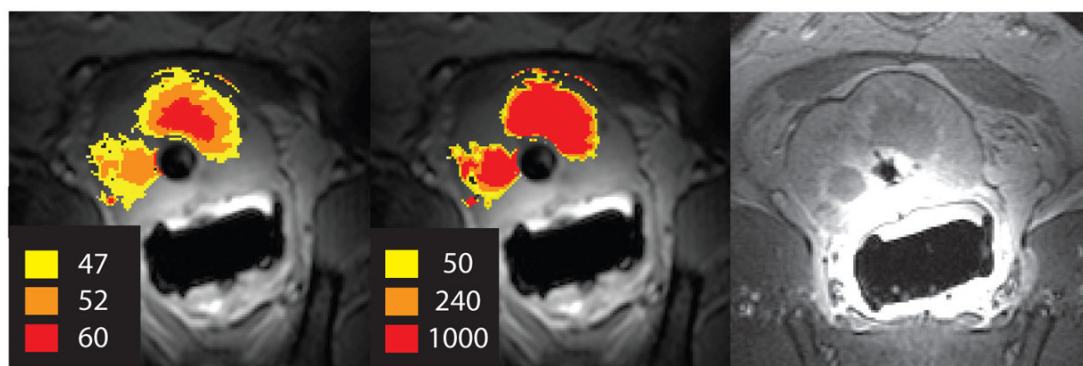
Maximum temperature (left) and thermal dose map (middle) from temperature measurements during in vivo canine prostate ablation with transurethral ultrasound show good agreement with the post-treatment contrast-enhanced image (right).
